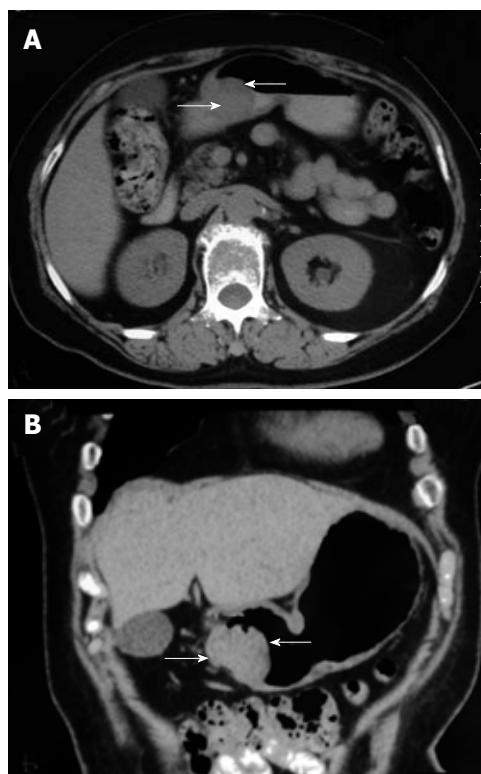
An abdominal computed tomography shows a low density, 2.4 cm \times 3.0 cm intramural mass of gastric antrum with tiny ulceration (arrows), which is suggestive of a gastric submucosal tumor, such as gastrointestinal stromal tumor. A: Cross section; B: Coronal section.
